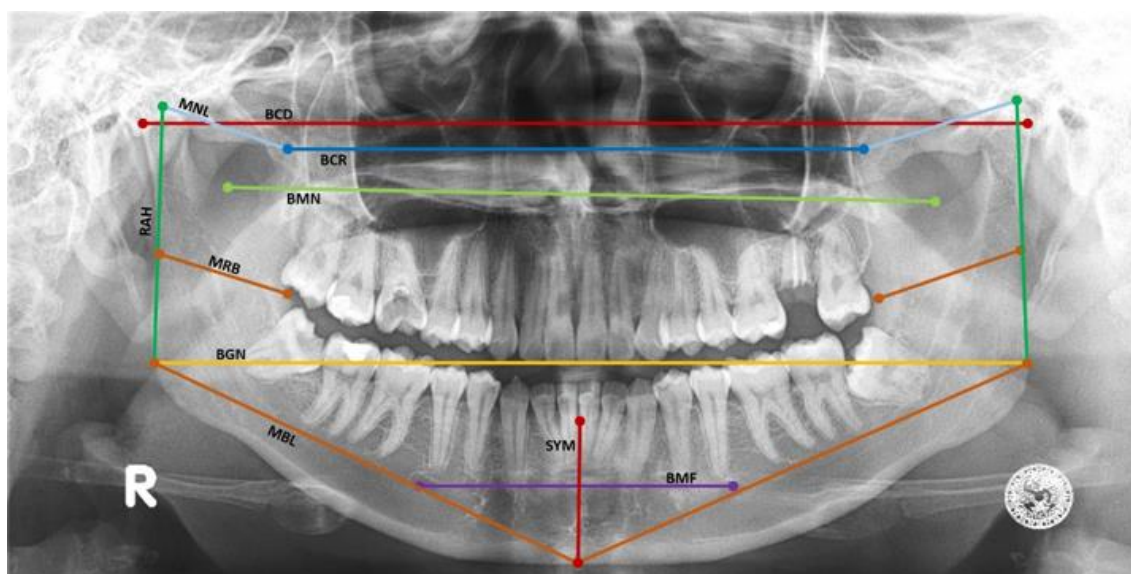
Ten mandibular parameters and the corresponding position on a digital panoramic radiograph for sex determination.
